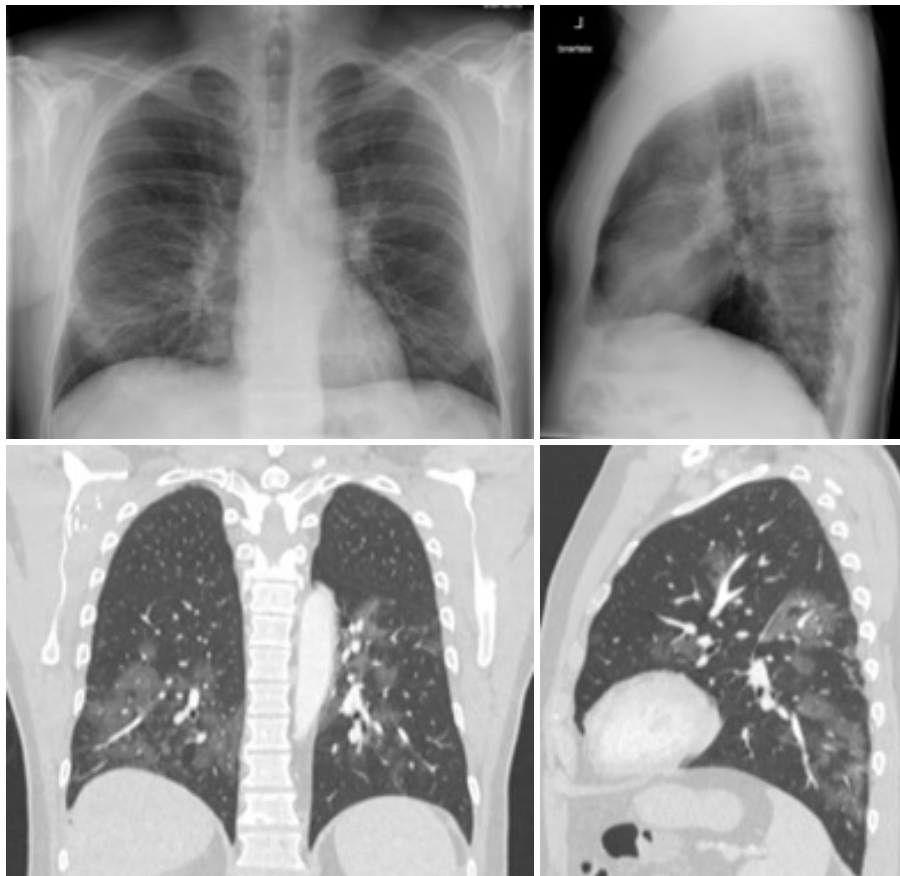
Comparison of Chest X-ray and CT-thorax at hospital admission, 10 days after onset of the first symptoms. Bilateral patchy reticular opacities with predominant involvement of the lower zones on the X-ray can be observed. Bilateral peripheral and peribronchovascular ground-glass opacities with basal predominant distribution in the CT-thorax are seen.
